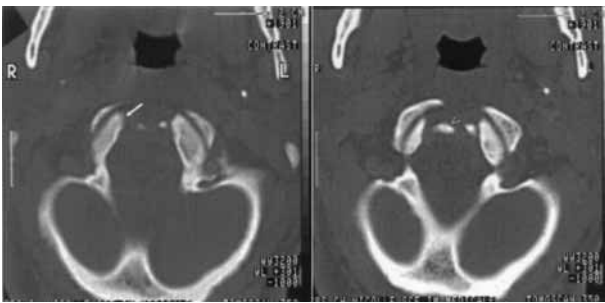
Axial CT at the level of foramen magnum. Left : two flake avulsions ; asymmetrical shape of occipital condyles due to right cortical defect (arrow). Right : this corresponds to bony avulsion of the right alar ligament (arrowhead).
